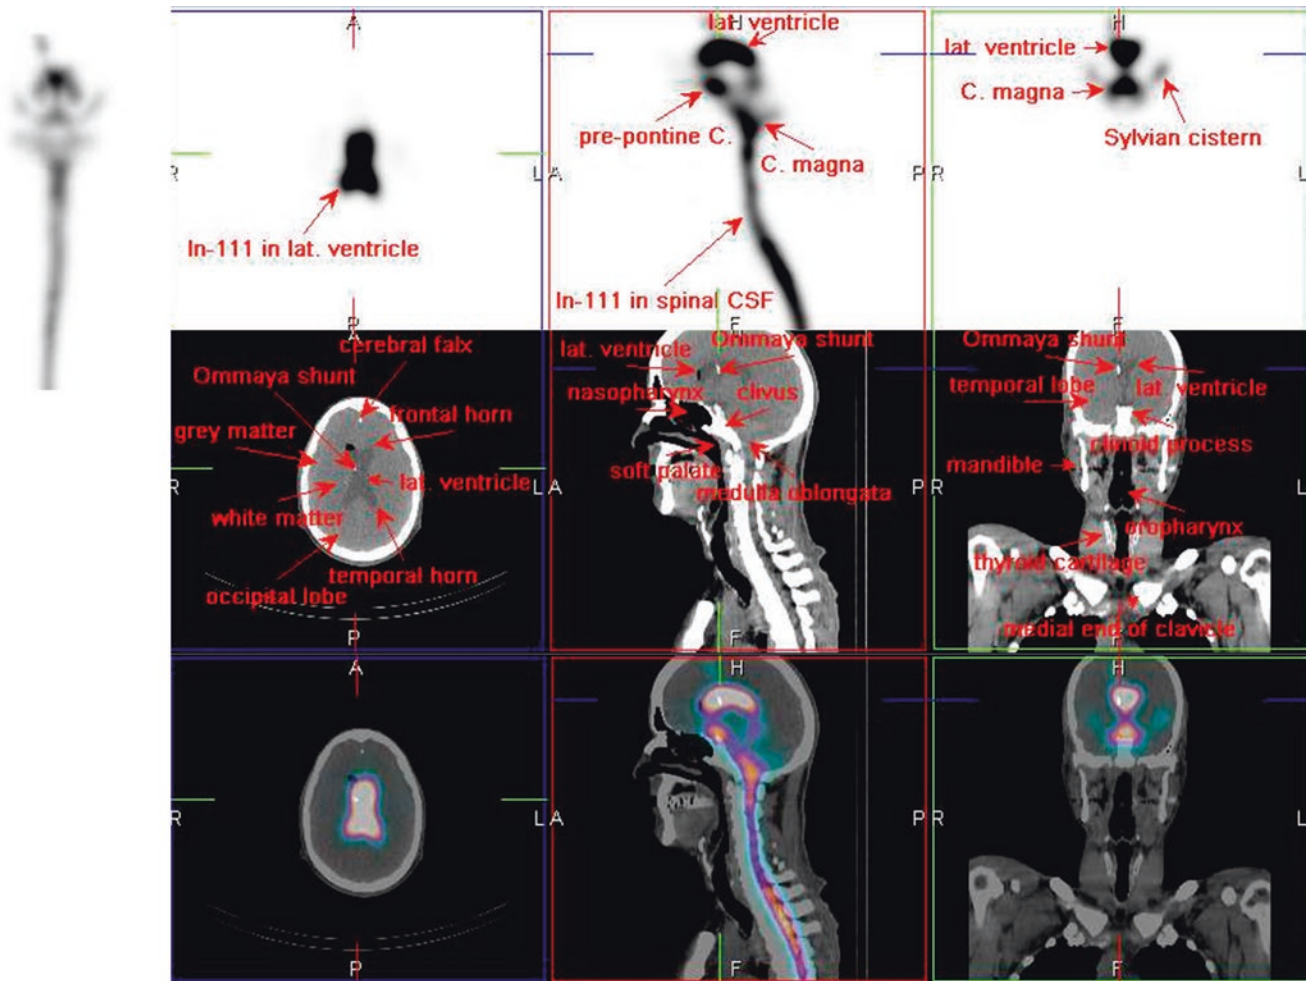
¹¹¹In-DTPA SPECT/CT
